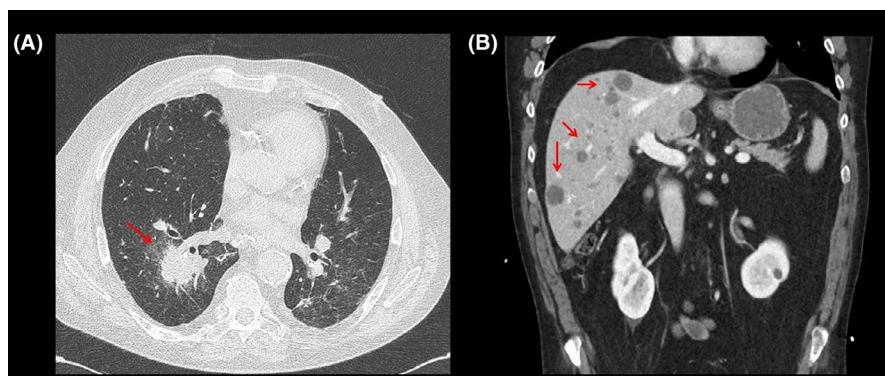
thoracoabdominal CT showing bilateral pulmonary opacities associated with a right lower lung mass (A) and multiple bi-lobar liver lesions (B)
